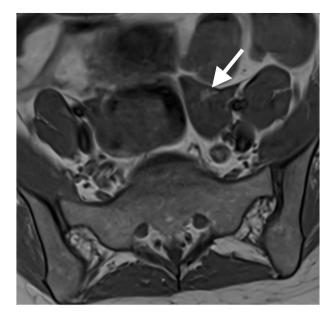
Subcentimeter fat-containing ovarian teratoma on axial MRI: T1 weighted image shows hyperintense lesion (arrow) which is conspicuous relative to T1 hypointense follicles and ovarian stroma. Fat or a small hemorrhage containing cyst could have this appearance on T1 weighted imaging.
